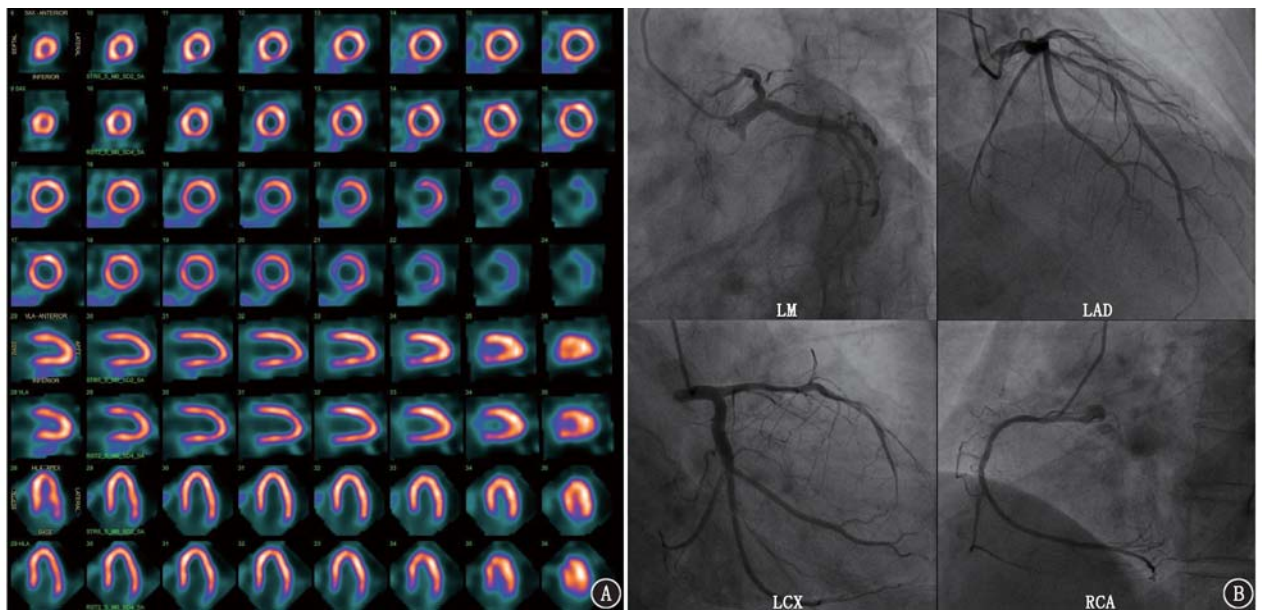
冠状动脉粥样硬化性心脏病患者(男, 57 岁)碲铊钼心脏专用 SPECT 仪心肌灌注显像(MPI)图及冠状动脉造影(CAG)图。A. MPI 表现为左心室下壁心尖部可逆性心肌缺血(第 1、3、5、7 排为负荷显像, 第 2、4、6、8 排为静息显像), 左前降支(LAD)、左回旋支(LCX)、右冠状动脉(RCA)血流储备分别为 2.24、2.85、2.25; B. CAG 示各支冠状动脉均未见狭窄(LM 为左主干)
